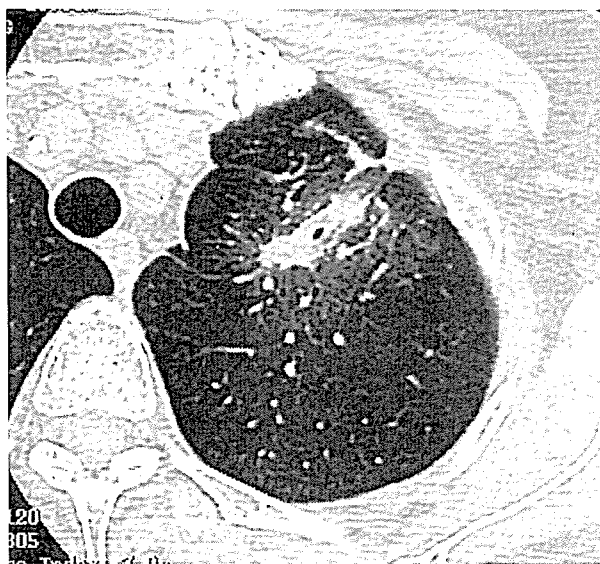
Computed tomography showing the lesion composed of the peripheral ground glass opacity and the central solid components.
